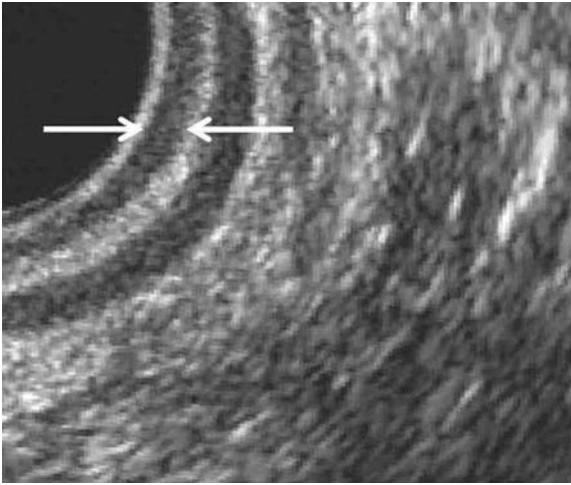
13. The muscularis submucosae ani can be sonographically identified as a low reflective band within the moderately reflective subepithelium (arrows)
